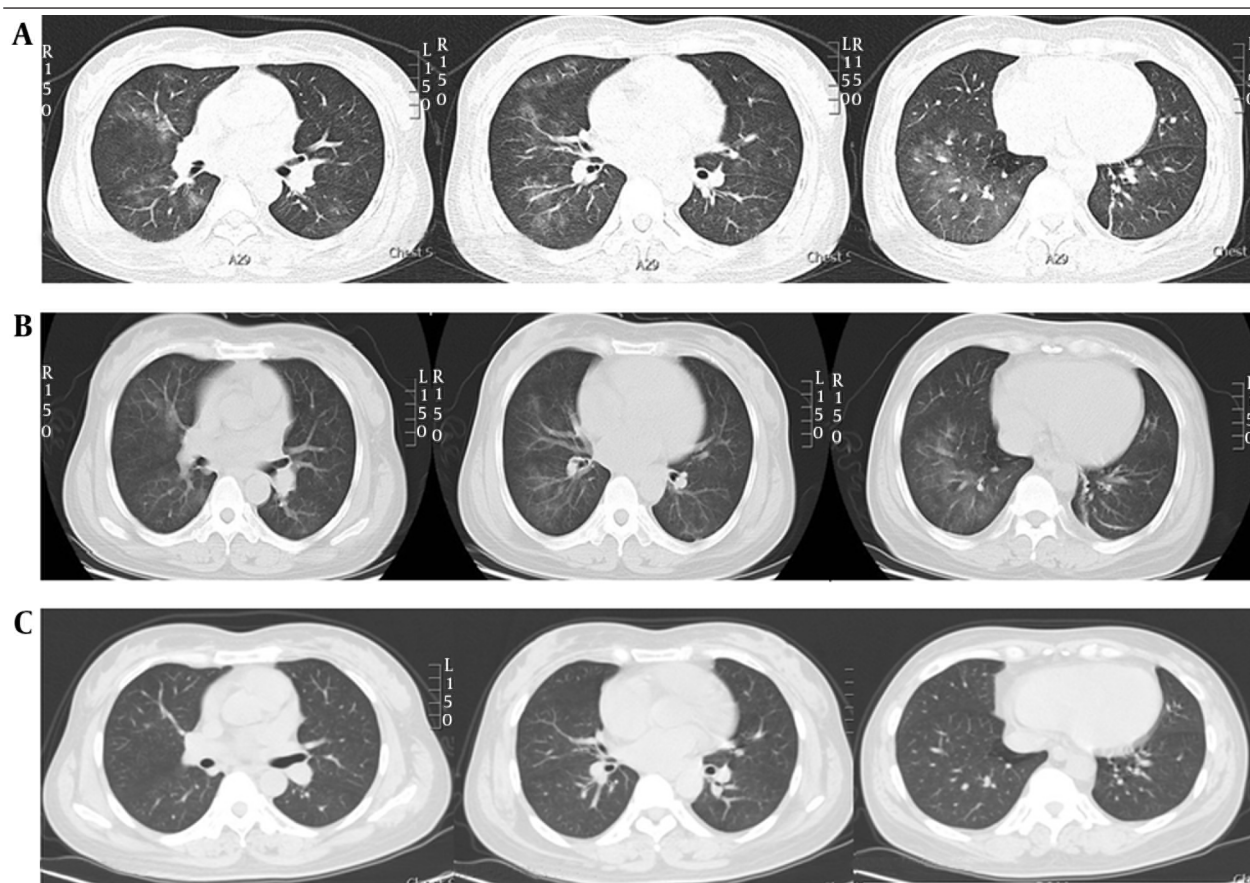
A, High-resolution chest computed tomography performed at admission, revealing diffuse bilateral alveolar infiltrates and ground-glass opacification, predominantly in the middle and lower lung fields, consistent with pulmonary hemorrhage; B, after 2 weeks of PTU withdrawal and steroid treatment, high-resolution chest computed tomography showed improvement in alveolar infiltrates and ground-glass opacity; C, after 6 weeks of PTU withdrawal and steroid treatment, high-resolution chest computed tomography showed restoration of the lung parenchyma, with the alveolar infiltrates and ground-glass opacity completely disappeared.
